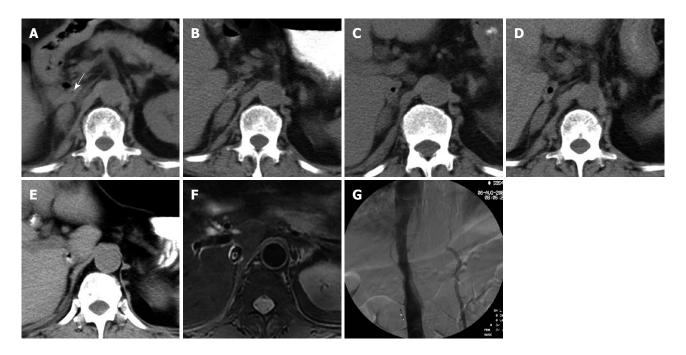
During the 2-mo hospital stay, a small, low-density air bubble appeared in the inferior vena cava (IVC) and gradually enlarged on follow-up computed tomography (CT) scans. Enteric contrast medium leaked into the IVC. Magnetic resonance imaging (MRI) clearly demonstrated the high-signal enteric contrast medium or thrombus and signal-void air bubbles. Cavography did not reveal the thrombus in the IVC. A: CT scan on the second hospital day. A low-density dot loomed up in the IVC (arrow). A mass in the right side adrenal gland was also seen; B: CT scan on the 19th hospital day. The low-density dot became more evident; C, D: CT scan on the 59th and 67th hospital day. The low-density dot (air bubble) was gradually enlarged; E: CT scan on the 73rd hospital day with water-soluble enteric contrast demonstrated air bubble surrounded by contrast medium in the IVC; F: MRI T2WI on the 74th hospital day demonstrated the high signal enteric contrast medium or thrombus and signal void air bubble in the IVC; G: Inferior vena cavogram on the 75th hospital day showed no evident thrombus in the IVC.
